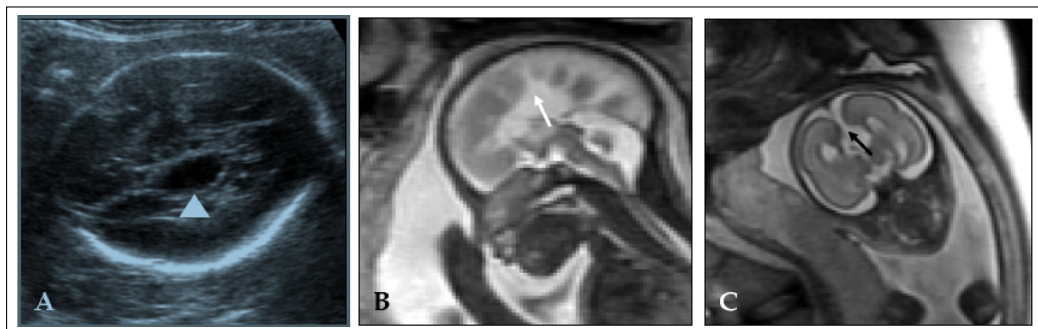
Comparison between ultrasound (A) and MRI (B, C) on the agenesis of the corpus callosum. MR images could depict the lack of connection of white matter, while ultrasound images couldn't show it [5].
